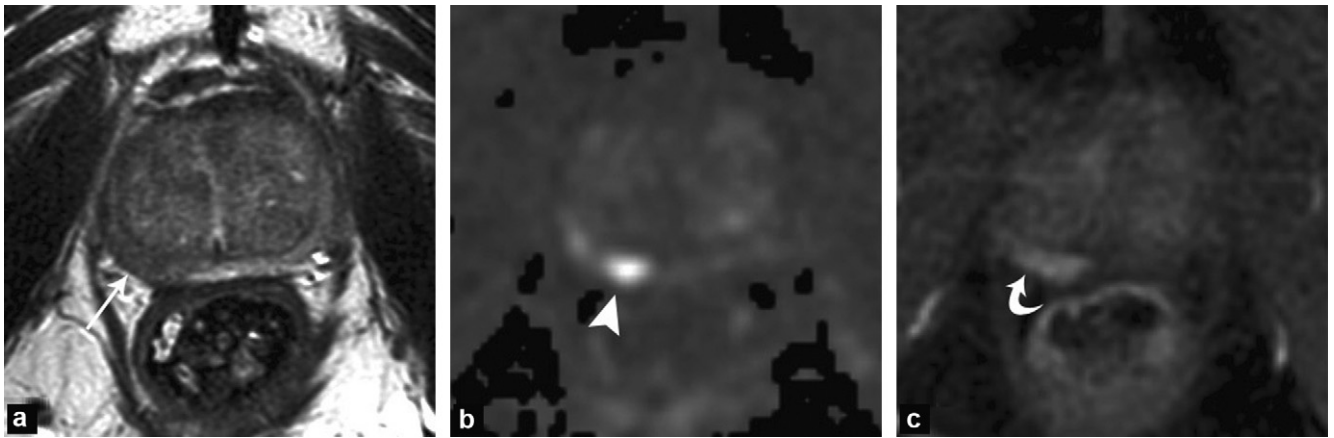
A 79-year-old patient who had had external beam radiotherapy (76 Gy) and hormone treatment 6 years previously for a Gleason 7 prostate adenocarcinoma. The PSA nadir was 0.6 ng/mL, then the level gradually climbed again to 2.7 ng/mL: a: T2-weighted axial magnetic resonance imaging (MRI) shows a suspect hypointense area in the right mid part of the peripheral zone (arrow); b: diffusion-weighted axial slice ($b = 2000 \text{ s/mm}^2$); this area exhibits clear diffusion restriction (arrowhead); c: the dynamic axial slice after contrast agent injection shows early enhancement (curved arrow). Targeted biopsies showed a right mid Gleason 7 adenocarcinoma.
